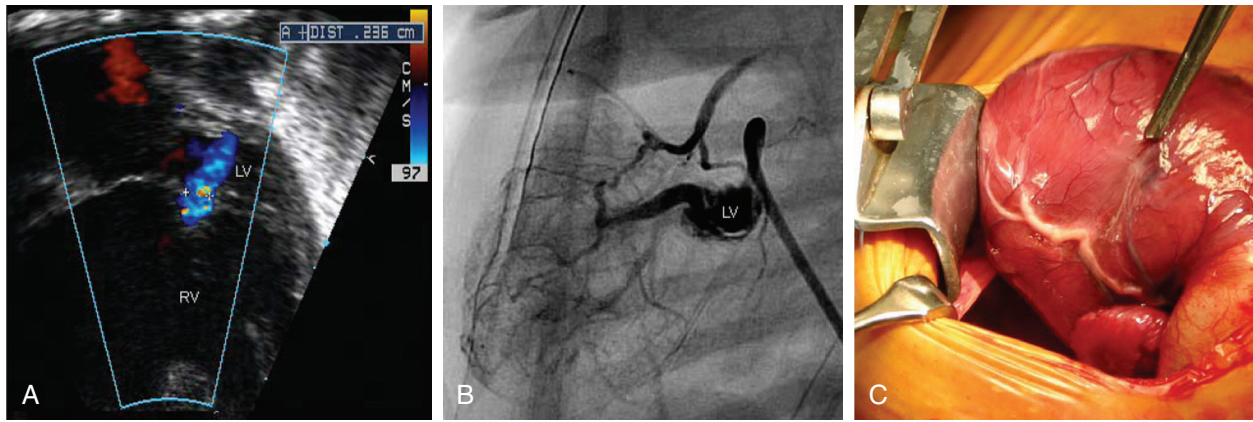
■ Diagnosis of left ventricle to coronary artery fistulas. A, Echocardiographic examinations often reveal flow “across” the interventricular septum and have been considered to represent ventricular septal defects. B, Angiographic demonstration of left ventricle to coronary artery fistulas with retrograde filling of the ascending aorta in addition to the right coronary artery system. C, Intraoperative examination has consistently revealed a small “duvet” or “pucker” in the myocardium, presumably at the site of the fistulas, with a thickened and corkscrew appearance of the epicardial coronary artery.
